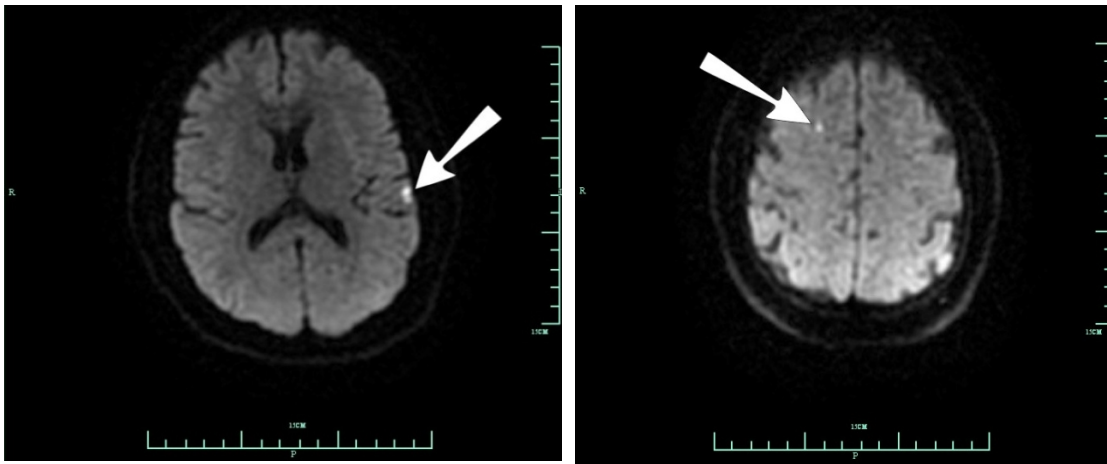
Brain MRI with and without gadolinium contrast: There are punctate foci of restricted diffusion in the right frontal lobe white matter and left anterior parietal cortex, consistent with small nonhemorrhagic acute infarct
